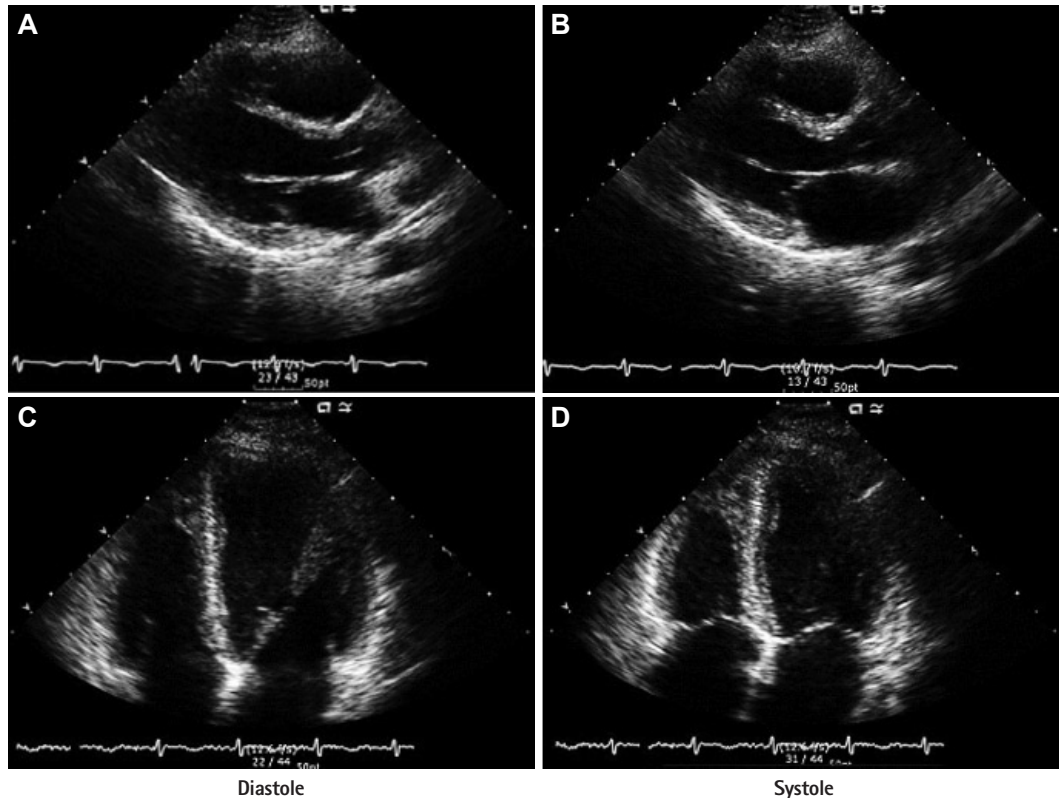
Transthoracic echocardiography at the time of pulmonary embolism shows severe left ventricular systolic dysfunction with hypokinesia of the base and mid ventricular segment and hypercontractility of the apex. A and B: parasternal long-axis view in diastole and systole. C and D: apical four-chamber view in diastole and systole.
